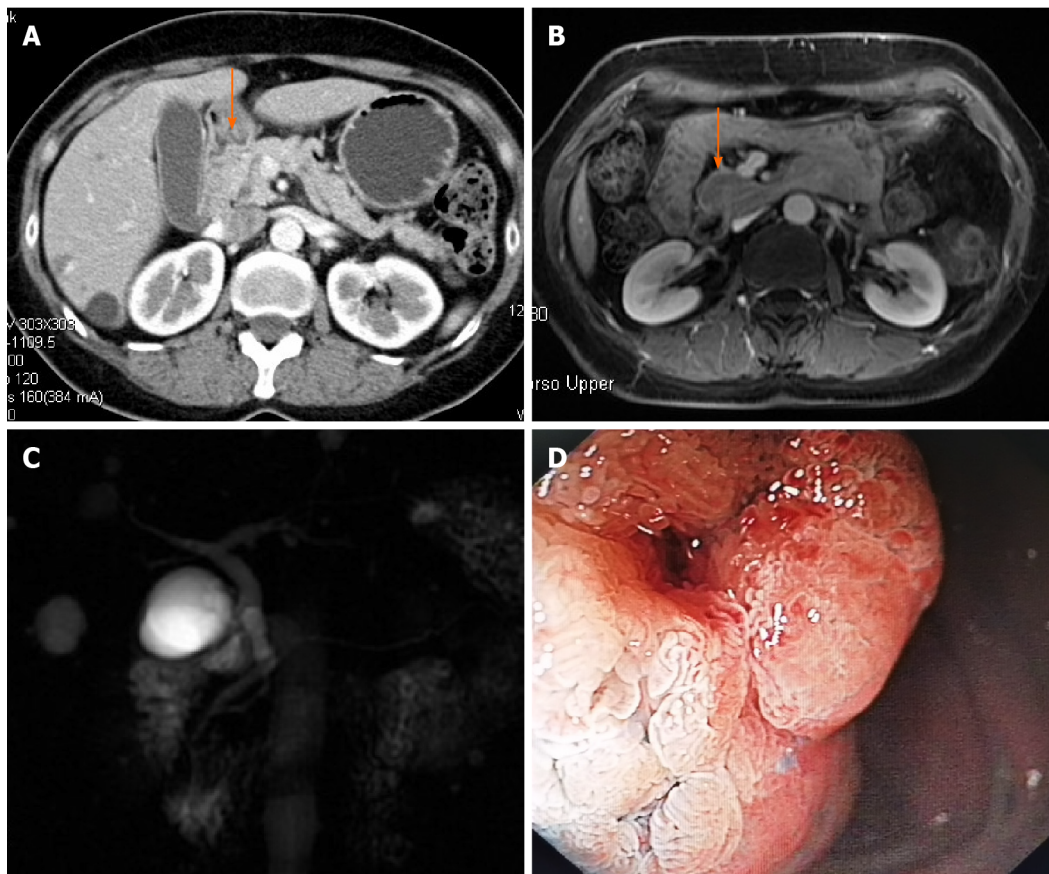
Preoperative examination of the ampullary tumor. A and B: Contrast-enhanced computed tomography and magnetic resonance imaging showing an enhanced lesion (arrow) located in the descending part of the duodenum; C: Magnetic resonance cholangiography revealing a mild dilation of the common bile duct, and no cut-off sign or stricture of either the bile duct or pancreatic duct; D: Endoscopic view of the ampullary adenoma.
